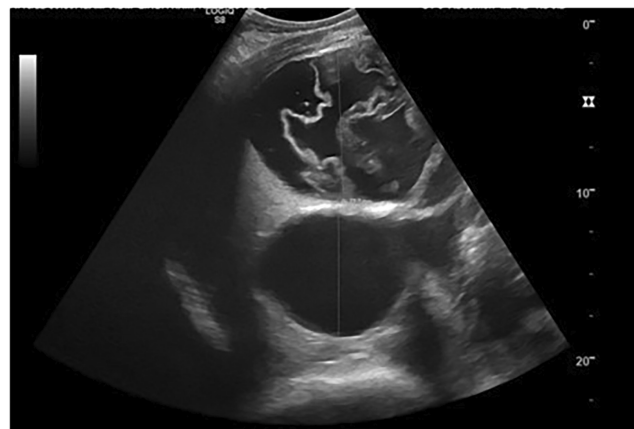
Sonogram obtained via transabdominal ultrasonography of the right liver. The diameter of the cysts are 9.5 and 7.7 cm, respectively.
